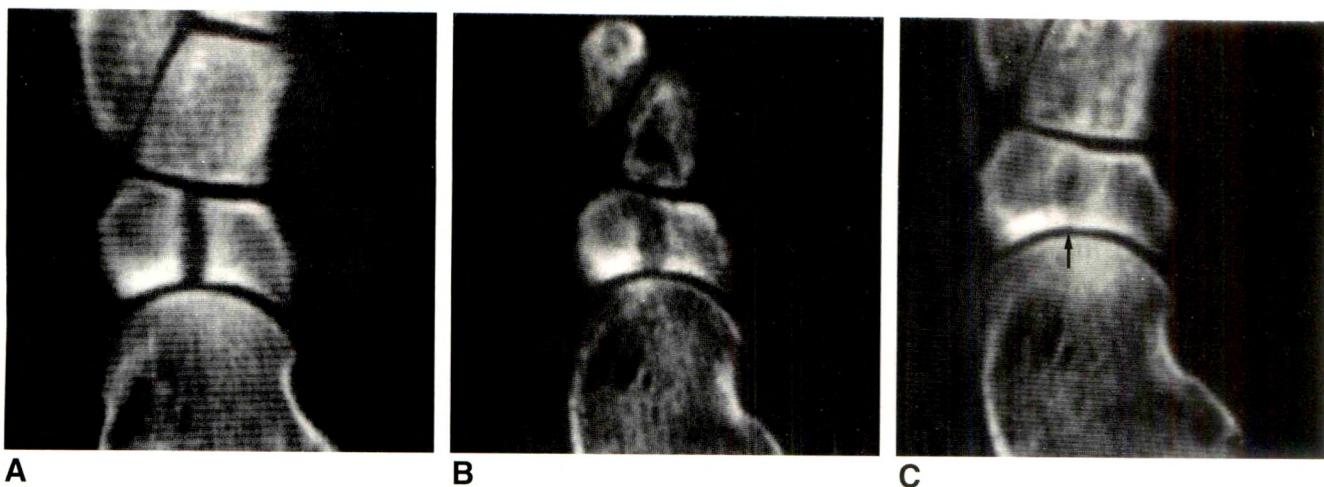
Nonunited partial fracture of right navicular bone in a 19-year-old female sprinter whose treatment was weight-bearing rest for 6 months. Coronal CT scan shows blurring of cortical defect and sclerosis (arrow) surrounding medullary portion of fracture, indicative of nonunion. Proximal marginal sclerosis is normal.
